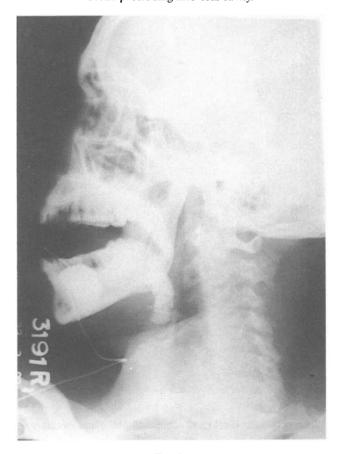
Roentgenogram showing stone.
